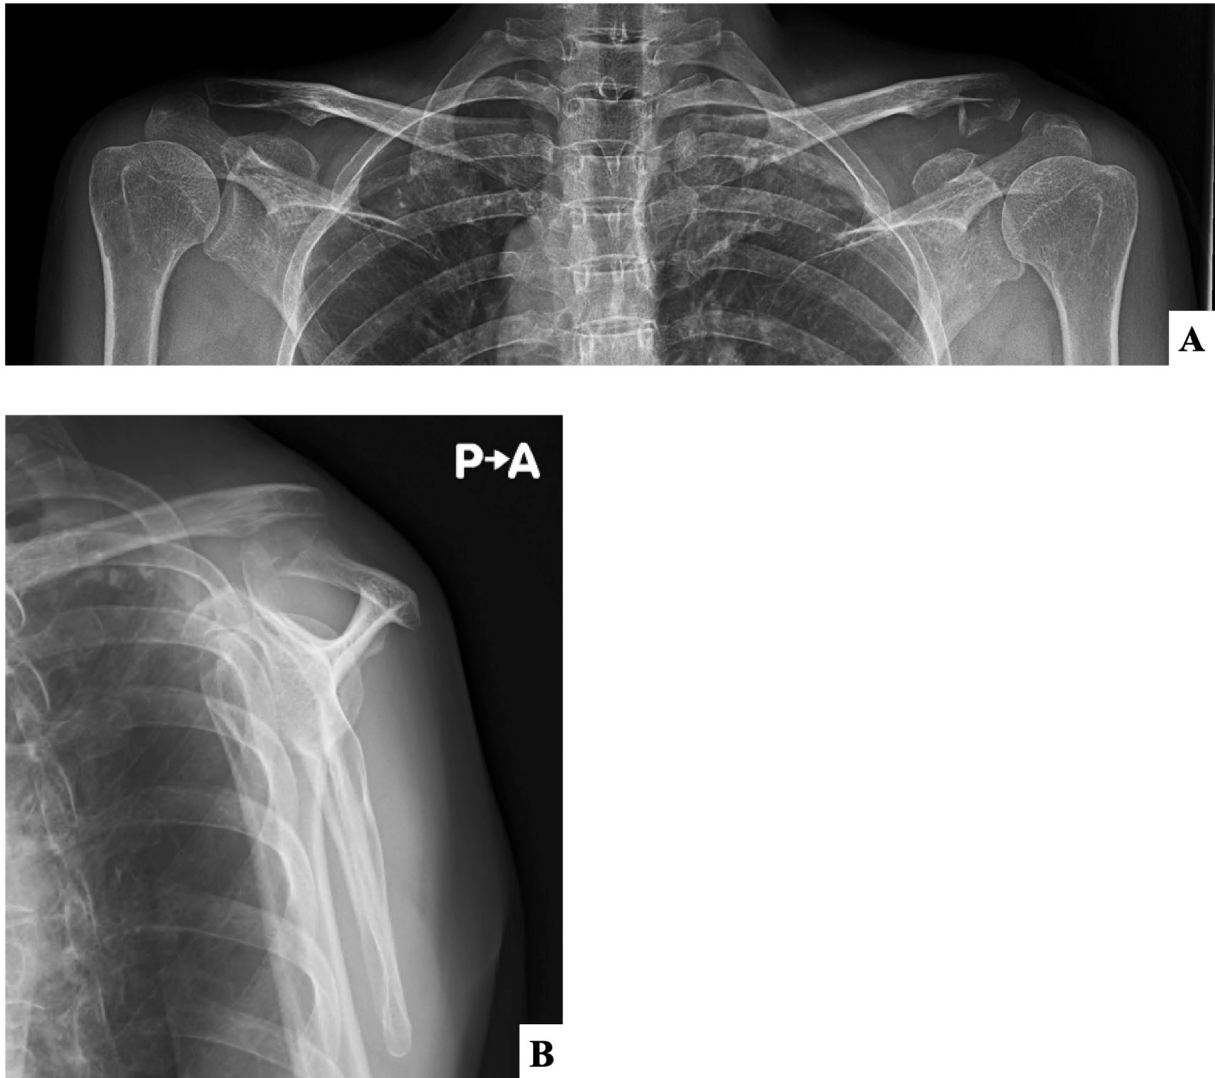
Pre-operative radiographs of (A) both clavicle in anteroposterior view and (B) left shoulder in lateral view.
